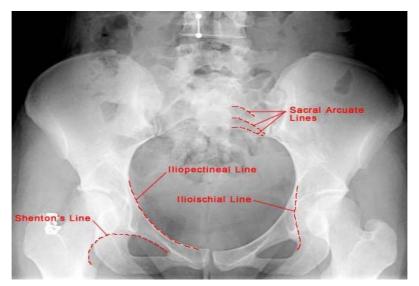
Plane radiograph of the pelvis and hip region, posteroanterior view, showing the Shenton's line.
